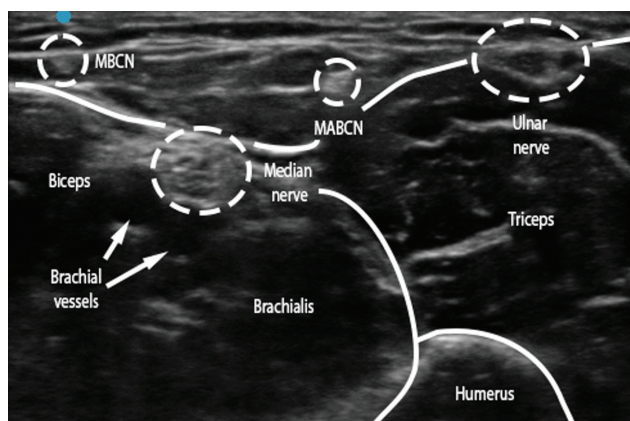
Ultrasound view of the medial antebrachial cutaneous nerve (MABCN), medial brachial cutaneous never (MBCN), ulnar, and median nerves. Probe was positioned on the distal third of the anterior surface of the arm. Anatomical landmarks include the biceps. Brachial vessels are seen as well and are compressible on examination.
